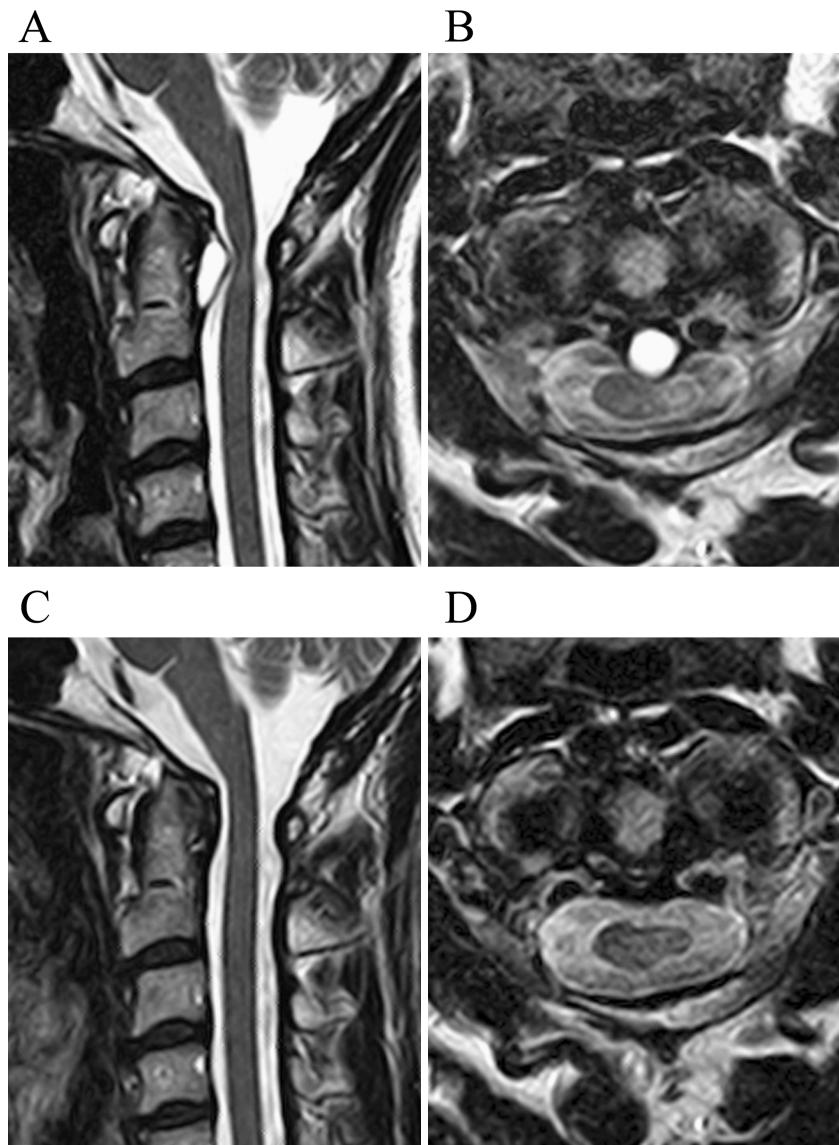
A and B, Sagittal and axial magnetic resonance images 2 months after the puncture demonstrating a significant reduction in the retro-odontoid cyst. C and D, Sagittal and axial magnetic resonance images 5 months after puncture showing complete disappearance of the retro-odontoid cyst.
